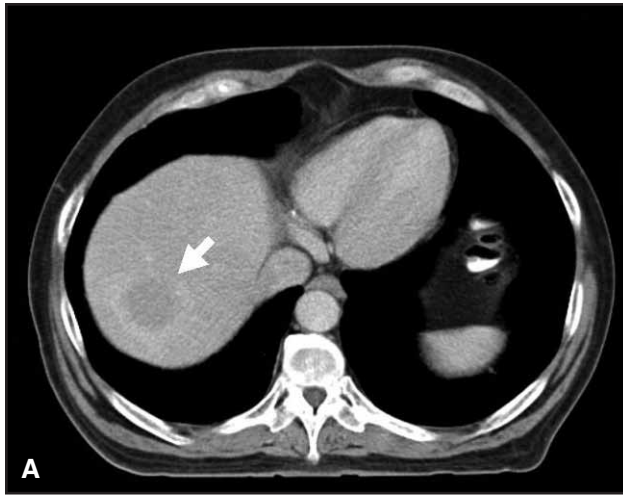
(A) Axial CT scan shows a peripherally enhancing low-attenuation mass in the superior aspect of the right lobe of the liver (arrow) prior to radiofrequency ablation. (B) Follow-up CT scan 1.5 years after ablation demonstrates satisfactory treatment with regression in size of the treated area (arrow) and no peripheral contrast enhancement to indicate recurrence or residual tumor.
